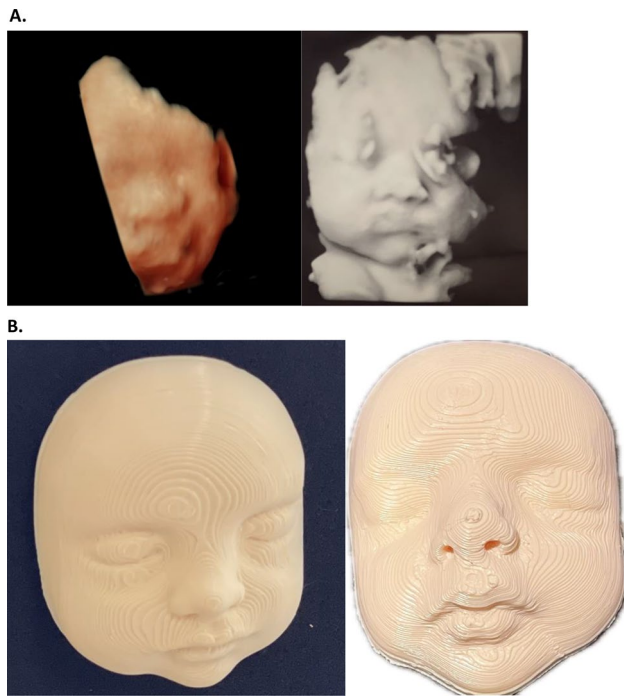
Patients were randomized and received 3D pictures (A) or 3D models (B) one week after their 3D ultrasound was performed
